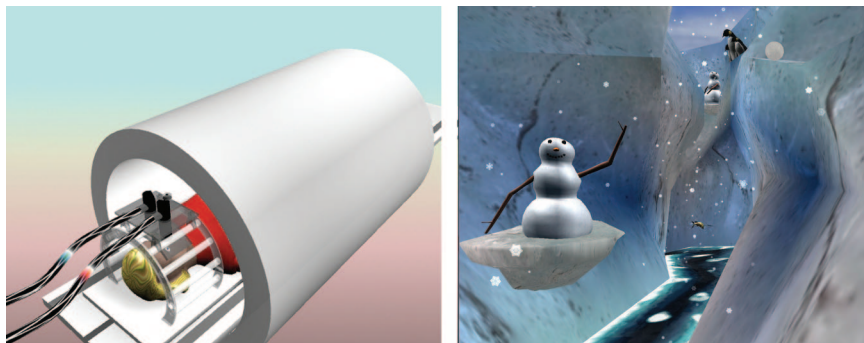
Graphic depiction of a subject wearing the nonferromagnetic virtual reality helmet while in the bore of the magnetic resonance imaging device (left). A snapshot of SnowWorld, the 3D virtual environment experienced by the subjects (right). (Left image by Duff Hendrickson, copyright Hunter Hoffman, University of Washington, right image by Ari Hollander, Imprintit.com, copyright Hunter Hoffman, University of Washington, 2006).
